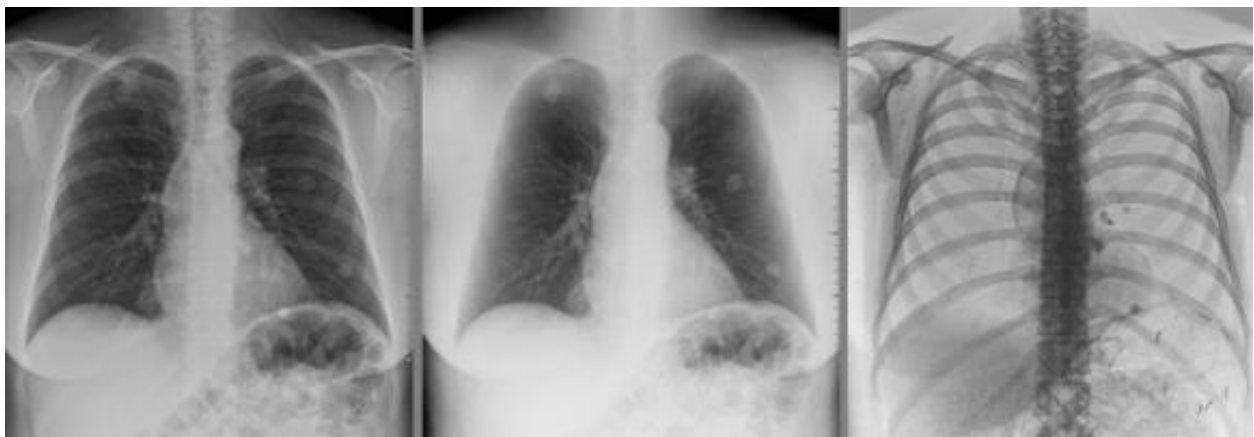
Dual energy radiography shows a chest radiograph with soft tissue (middle) and bone density (right)
